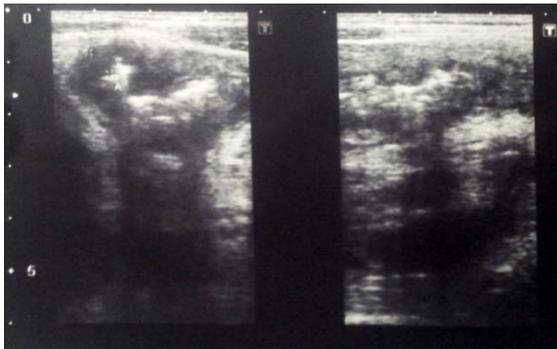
Ultrasonography (USG) of abdomen showing thickening of caecum
